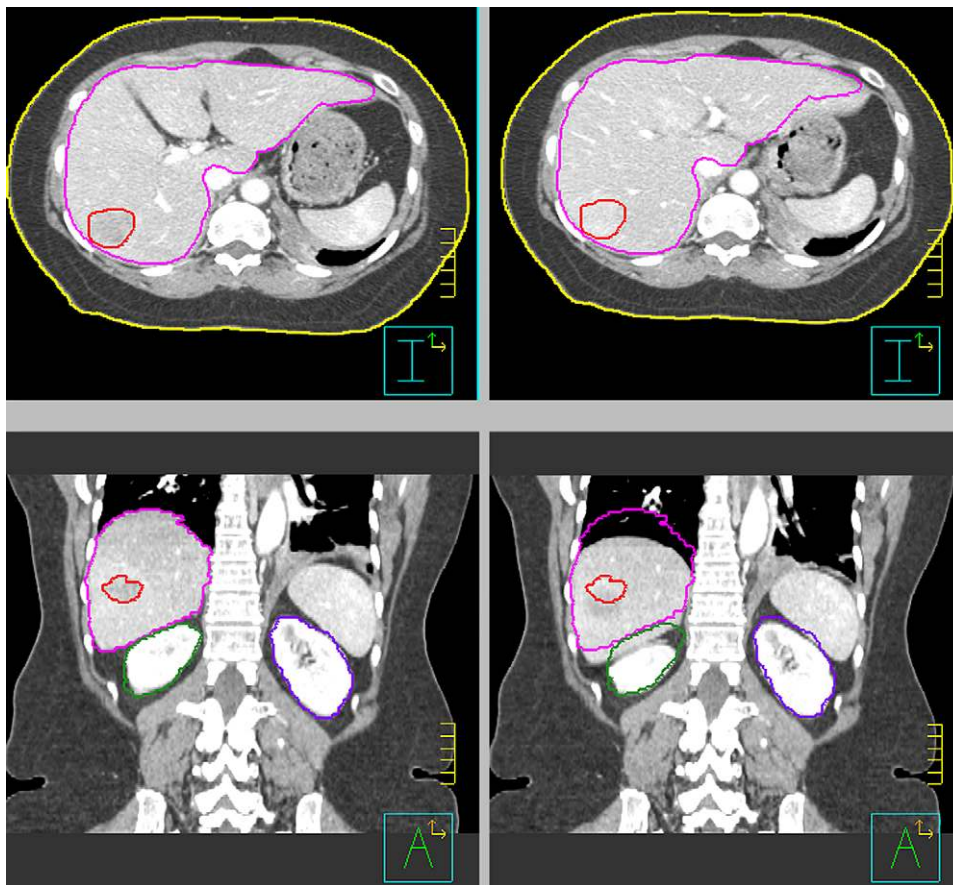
Exhale, 50% phase (left) and inhale, 0% phase (right) reconstructions from the four-dimensional computed tomography images obtained for the example liver patient. The liver (pink), tumor (red), and kidneys (green and purple) contoured on the exhale images are overlaid onto the inhale images for reference.
